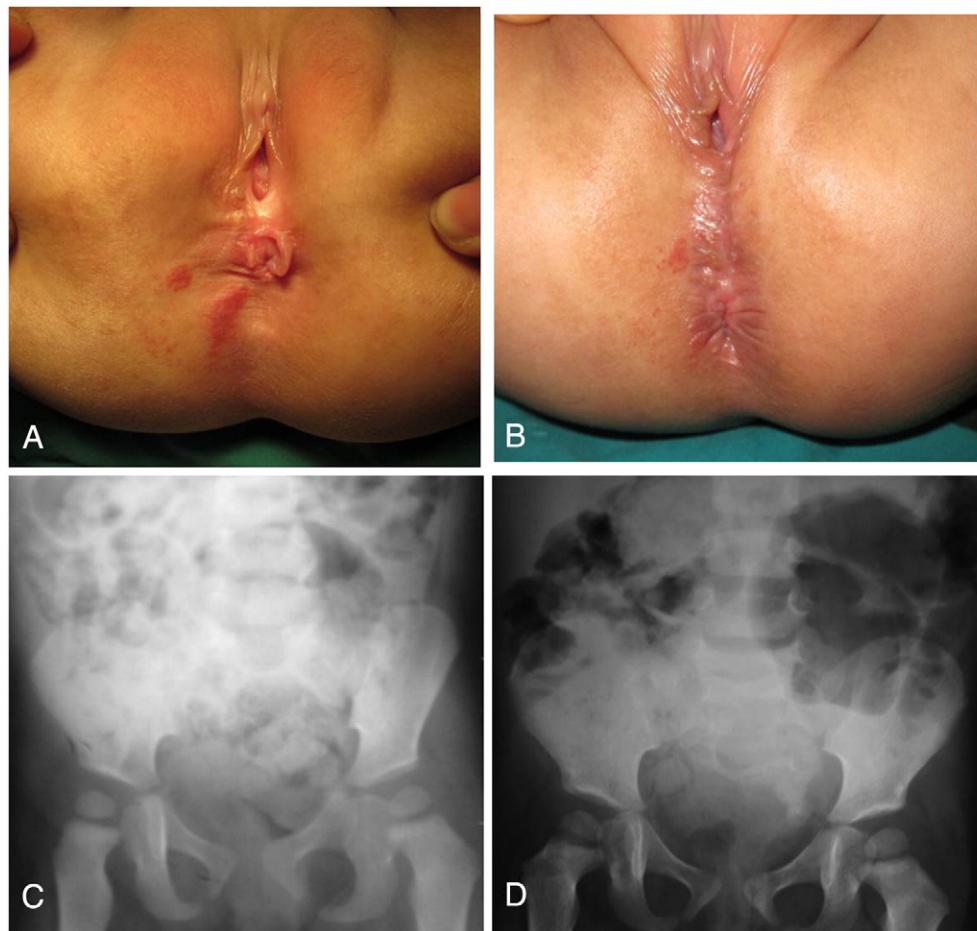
A 24-month-old female presenting with constipation and ventrally displaced anus (A). B) Postoperative picture of the same patient after limited PSARP to correct the position of the anorectum. C) Preoperative plain X-ray anteroposterior view showing the stool load in the pelvis masking the sacral defect. D) The 'scimitar' sacral deformity in the postoperative plain X-ray has become apparent after correction of constipation, providing the clue for the diagnosis of Currarino syndrome.
